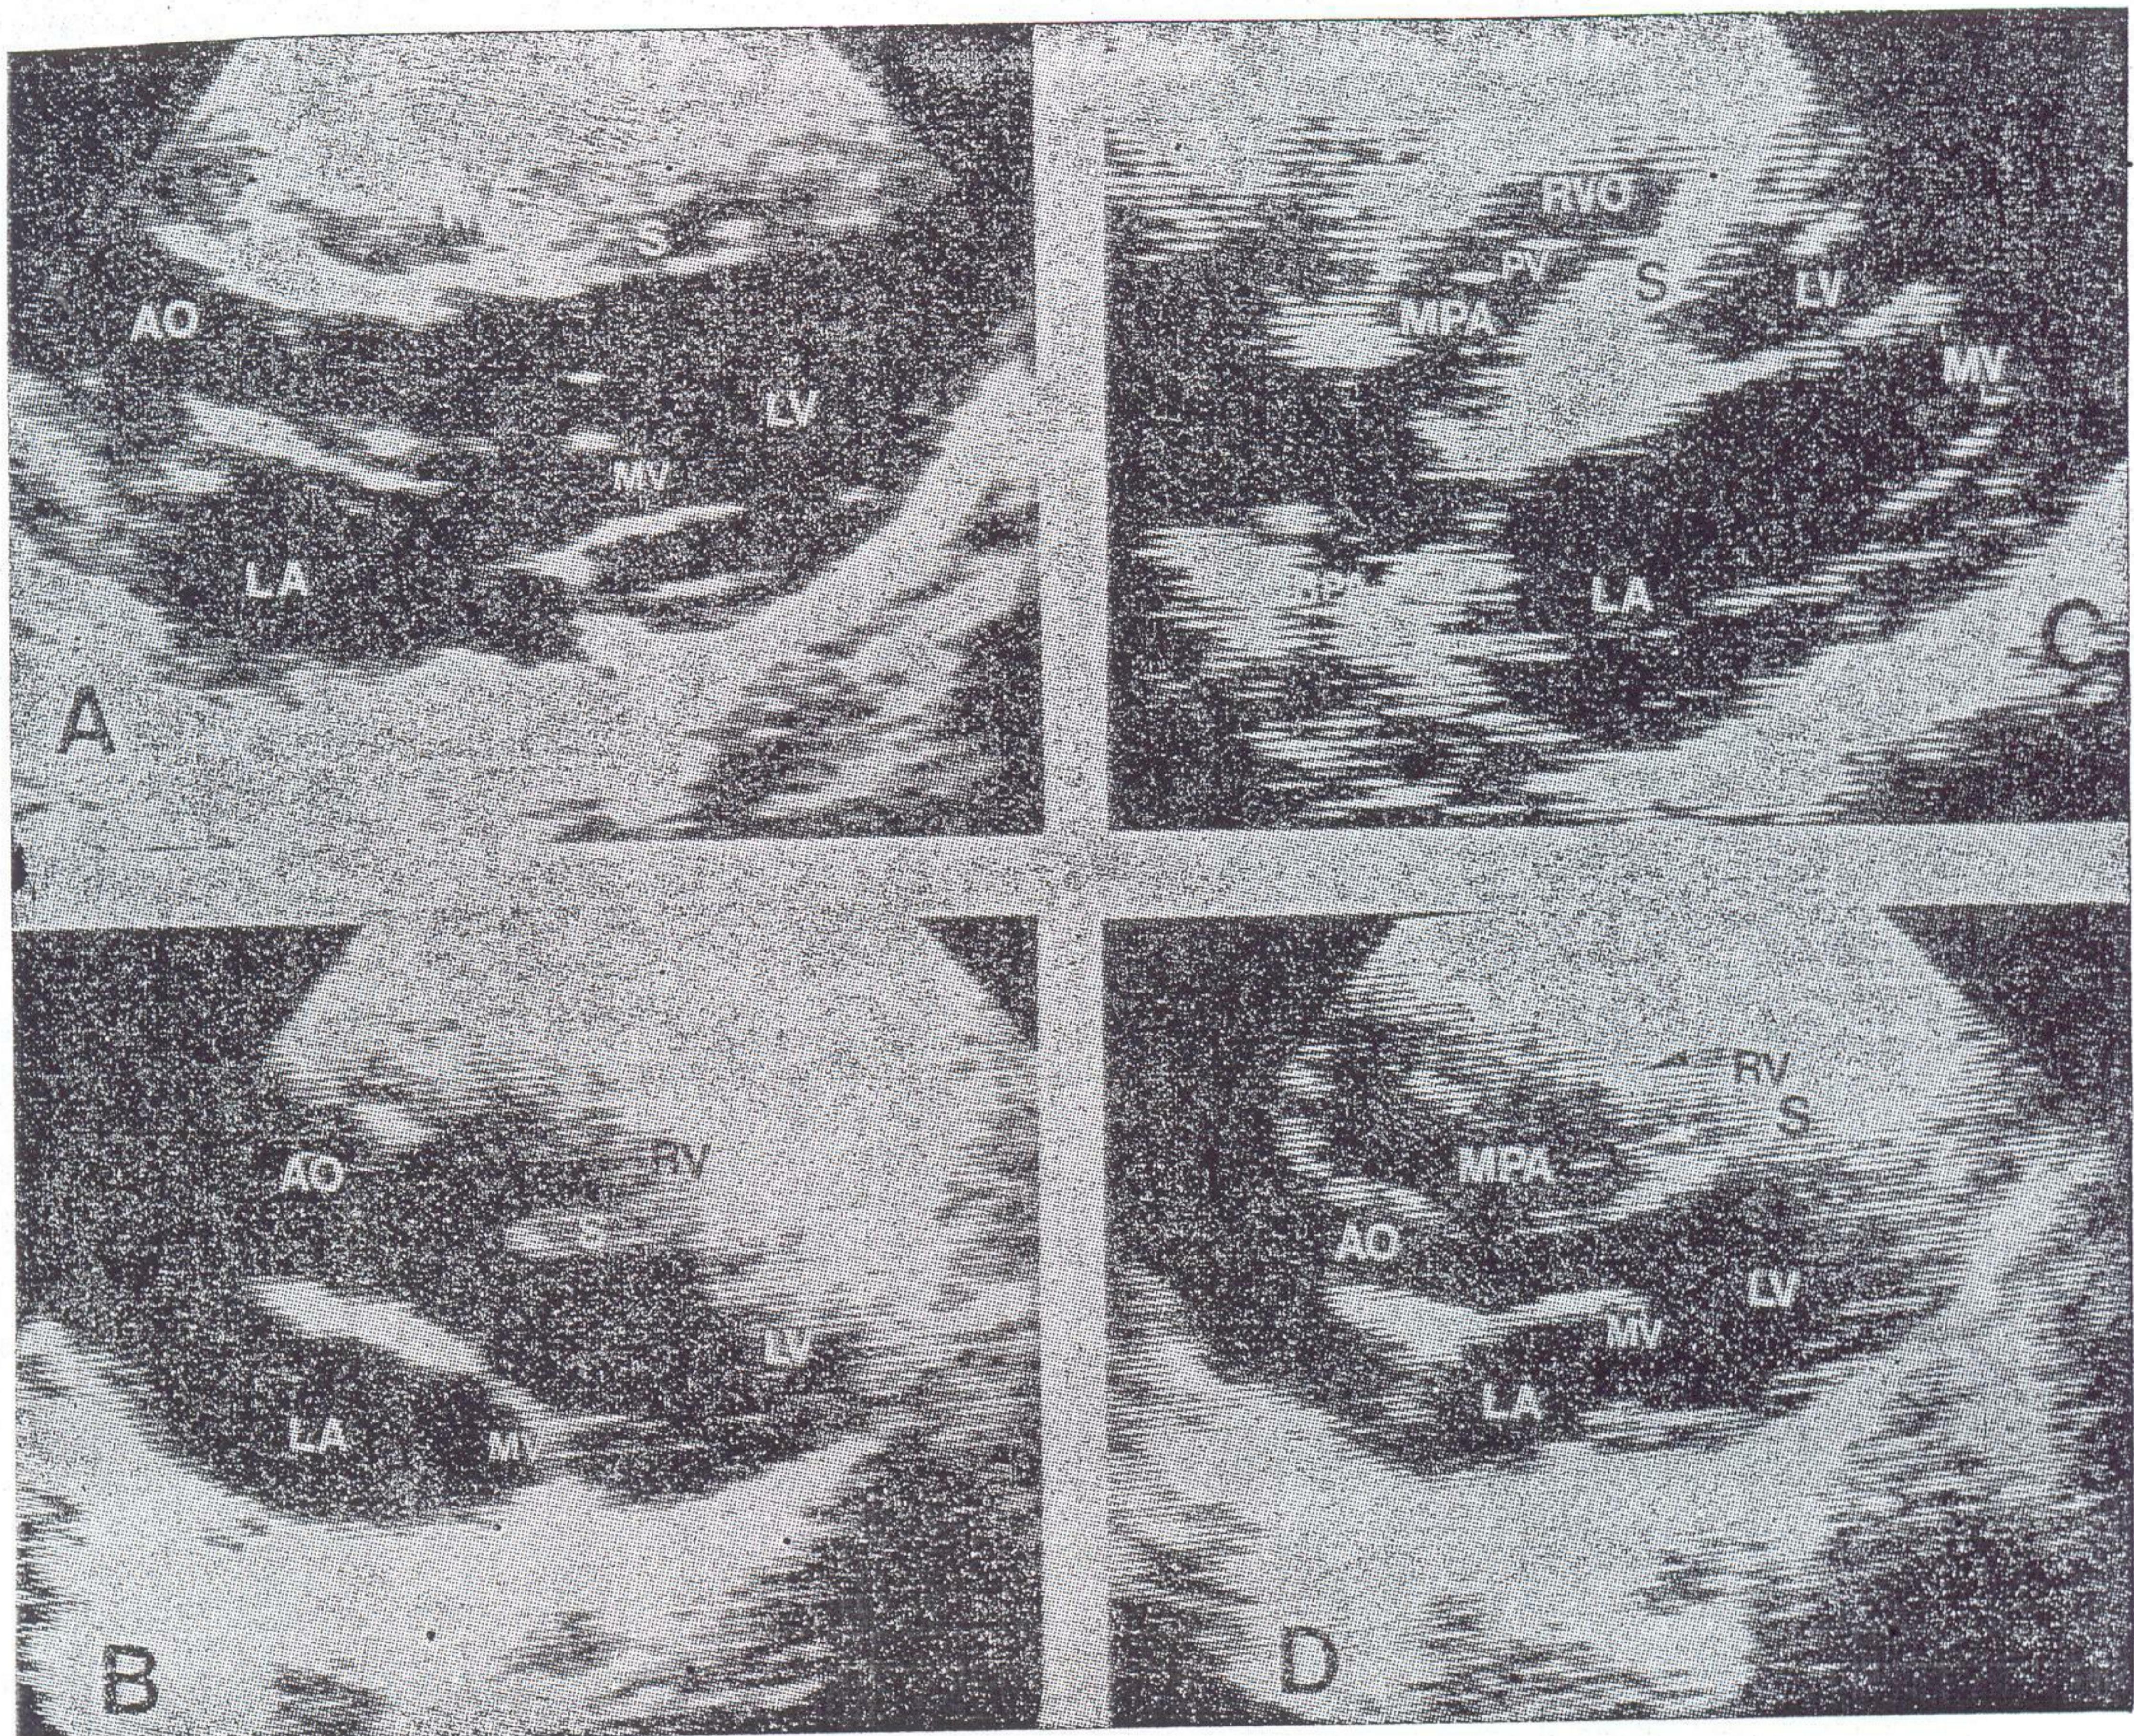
A, C, Left ventricular echocardiogram in early diastole from high left parasternal location in a normal child, and C, D, in patient with tetralogy of Fallot (Case 11). A, With the sector beam directed inferiorly and medially, the left ventricle (LV) and aorta (AO) are imaged together with a small portion of right ventricular outflow tract (RVO). Mitral valve (MV) is seen in slightly open position. C, Leftward and superior tilting of the transducer from the above position images the right ventricular outflow tract (RVO) and main pulmonary artery (MPA) and its continuation into the right pulmonary artery (RPA) above the left atrium (LA). B, Left parasternal view with sector beam as in A, shows overriding of the aorta above the ventricular septum (S), and D, slight superior tilting of transducer images hypertrophied infundibular muscle (arrows).
